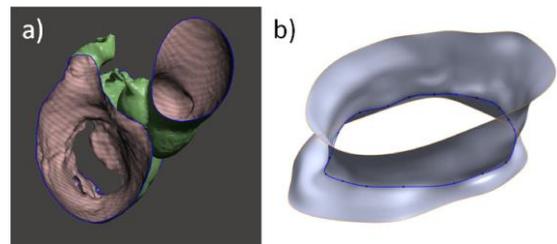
Example of 3D reconstruction of mitral valve from CT scan at the end of the diastolic phase a) and 3D model of the annulus b)
